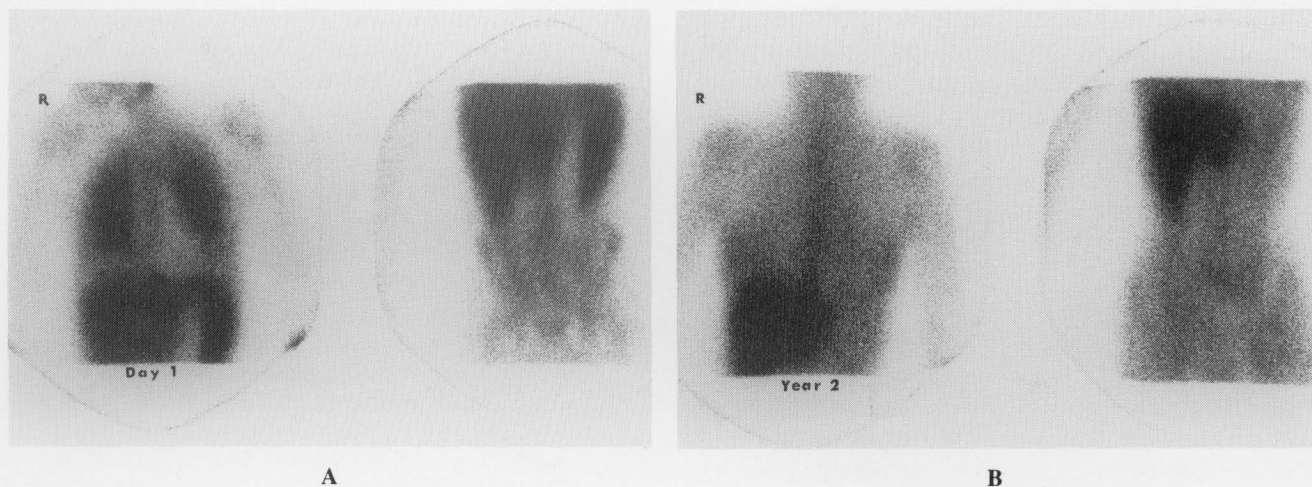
A & B: A baseline Ga-67 scintigraph shows diffuse lung parenchymal activity and hepatosplenomegaly with diffuse intense splenic activity (Stage IV (B)). The scintigraph obtained 2 years later shows complete resolution of lung activity and normal sized liver and spleen.
